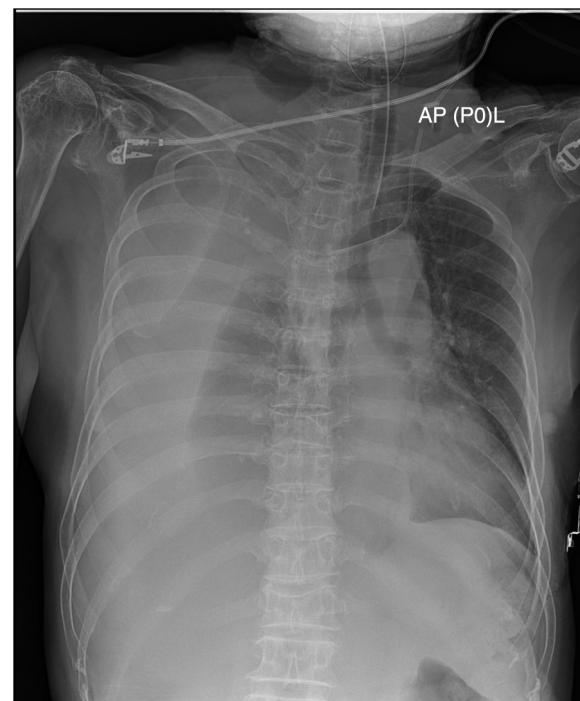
Chest radiograph. The chest radiograph shows a large hemothorax in the right thoracic cavity.
